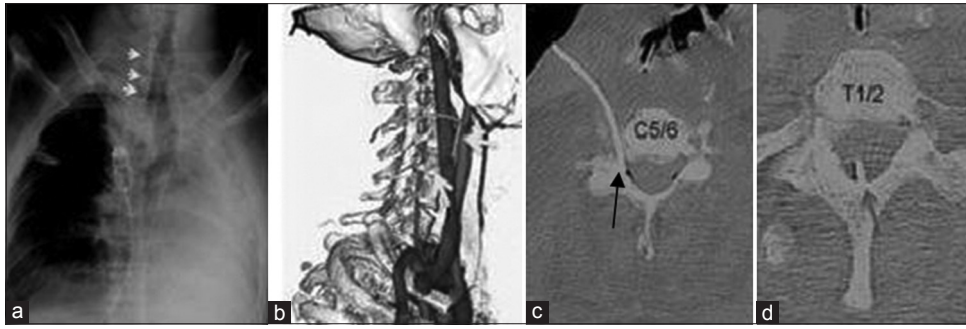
Catheter misplacement to the extradural space.^[41] Cervical computed tomography scans demonstrate that the central venous catheter has penetrated the posterior aspect of the internal jugular vein. (a) Chest radiograph reveals that the tip of the central venous line (arrows) runs inside the normal route of the internal jugular vein and appears to overlap with the cervical spine (arrows). (b) The cervical computed tomography scan demonstrates that the catheter travels posterior to the carotid artery (arrows). (c) The cervical computed tomography scan shows that the catheter penetrates the prevertebral fascia (arrow). (d) The image indicates that the catheter enters the intervertebral foramen (arrow).
